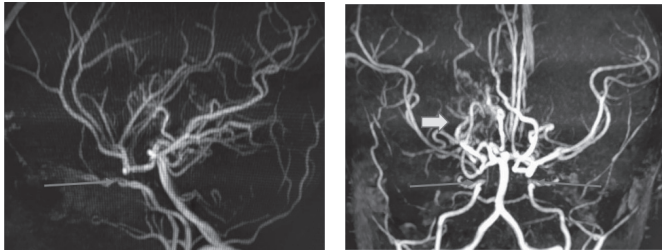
CT angiogram 3D volume rendered image
